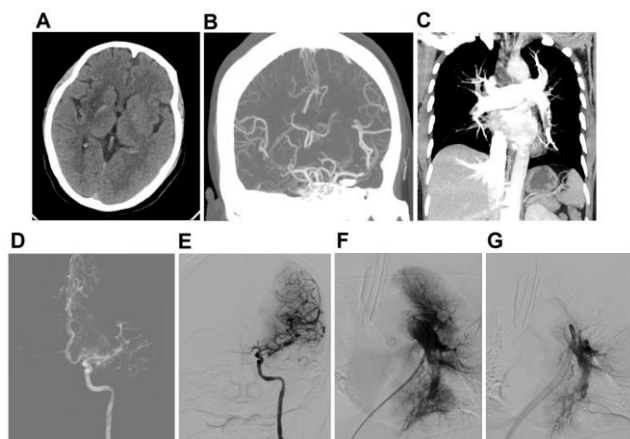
Imaging of the 4th stroke. A. 4th NCCT; B. CTA revealed L-MCA occlusion; C. Both pulmonary arteries thrombus identified with most one in the L side; D. Distal L-M1 occlusion in the DSA; E. TICl 3 revealed after aspiration; F. Angiography in the L-PA confirmed the diagnosis in CTA; G. L-PA after some aspirations
